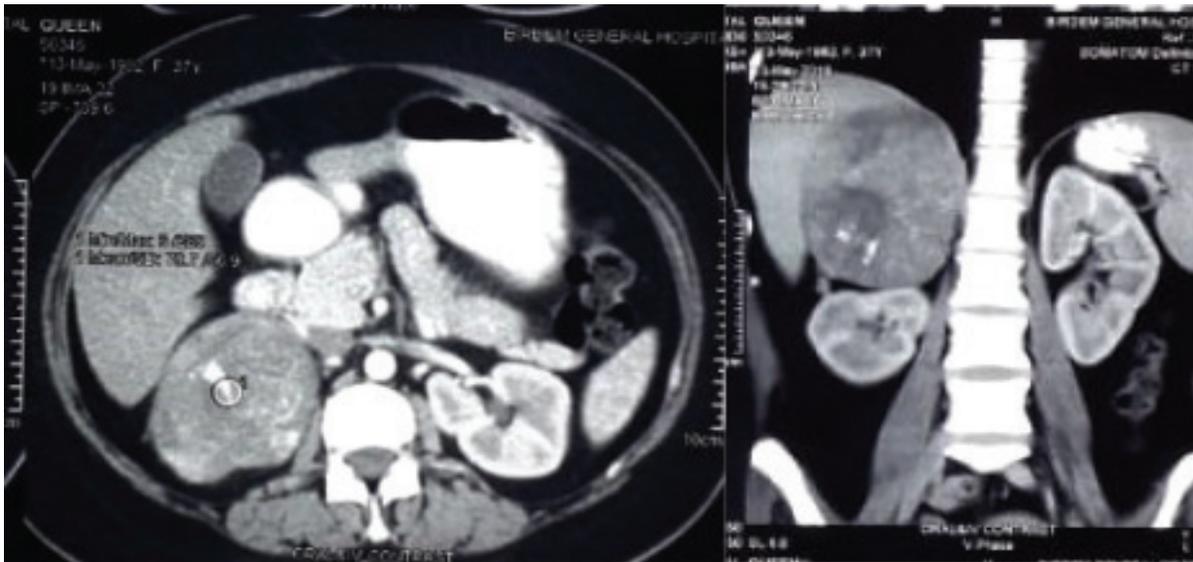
& 1b Computed tomography images showing mixed density mass with flecks of calcification in right adrenal gland
